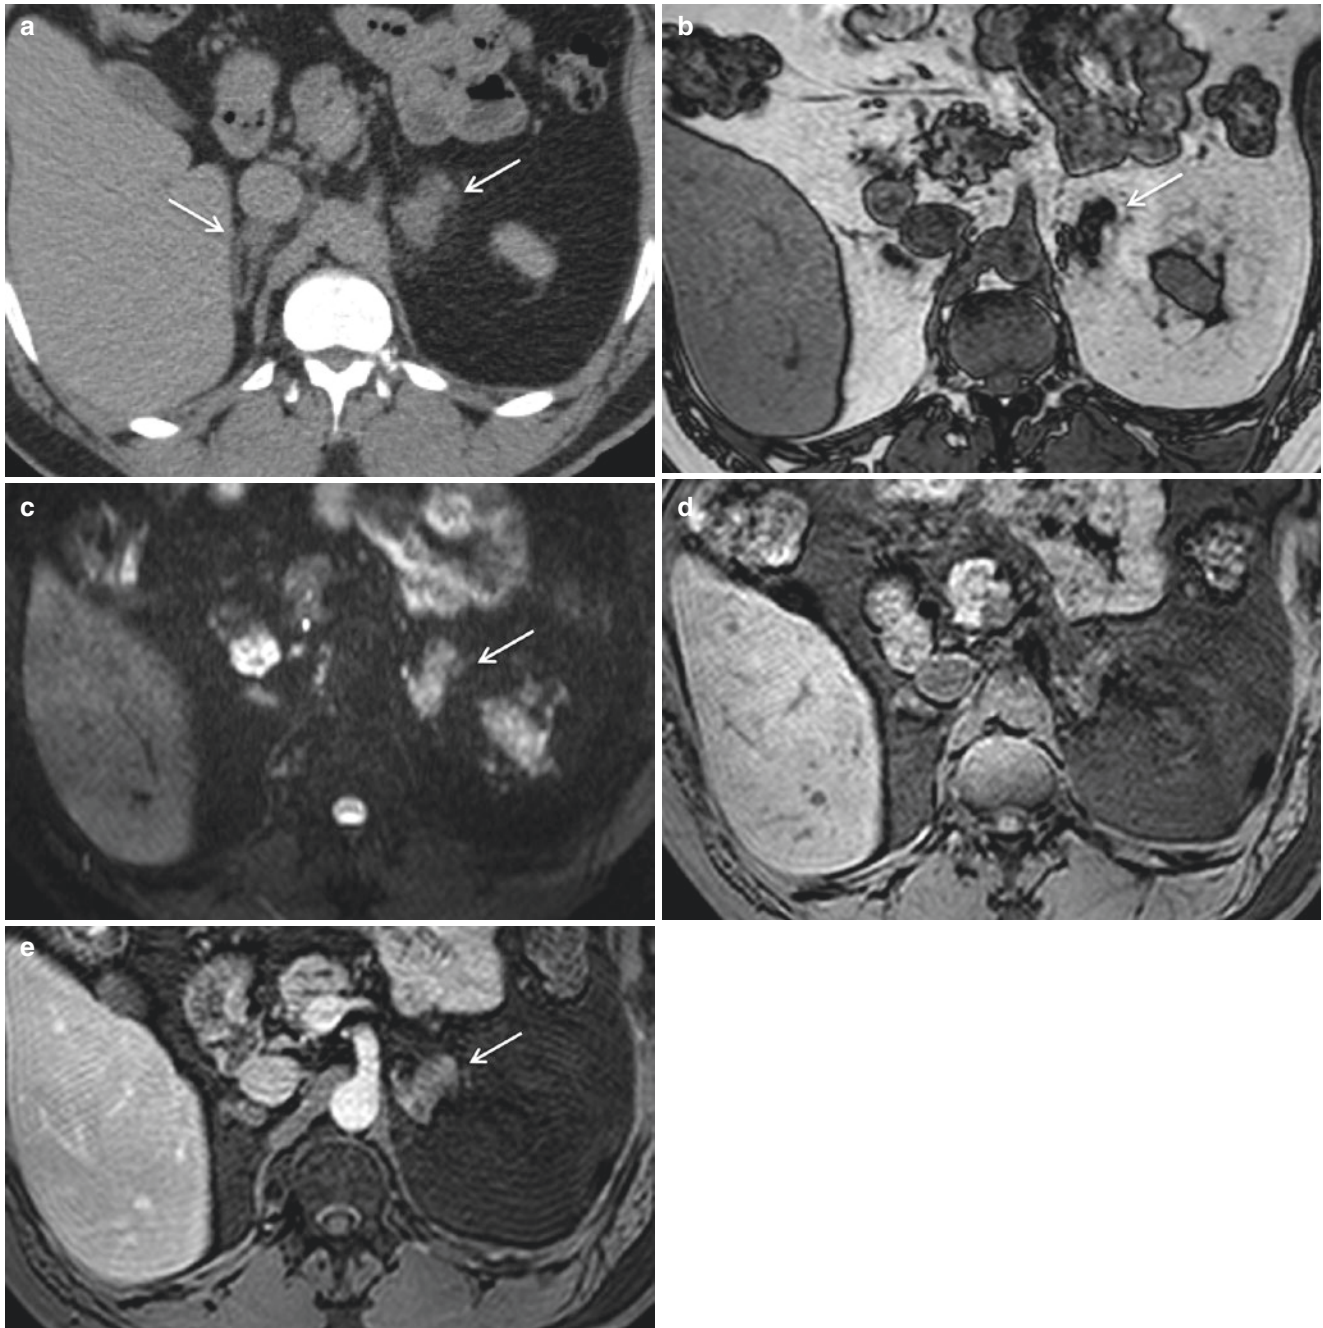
Adrenal hyperplasia. Diffuse enlargement of both adrenal glands, most evident on left adrenal (*white arrows*), on CT (a), and MRI (b-e)
